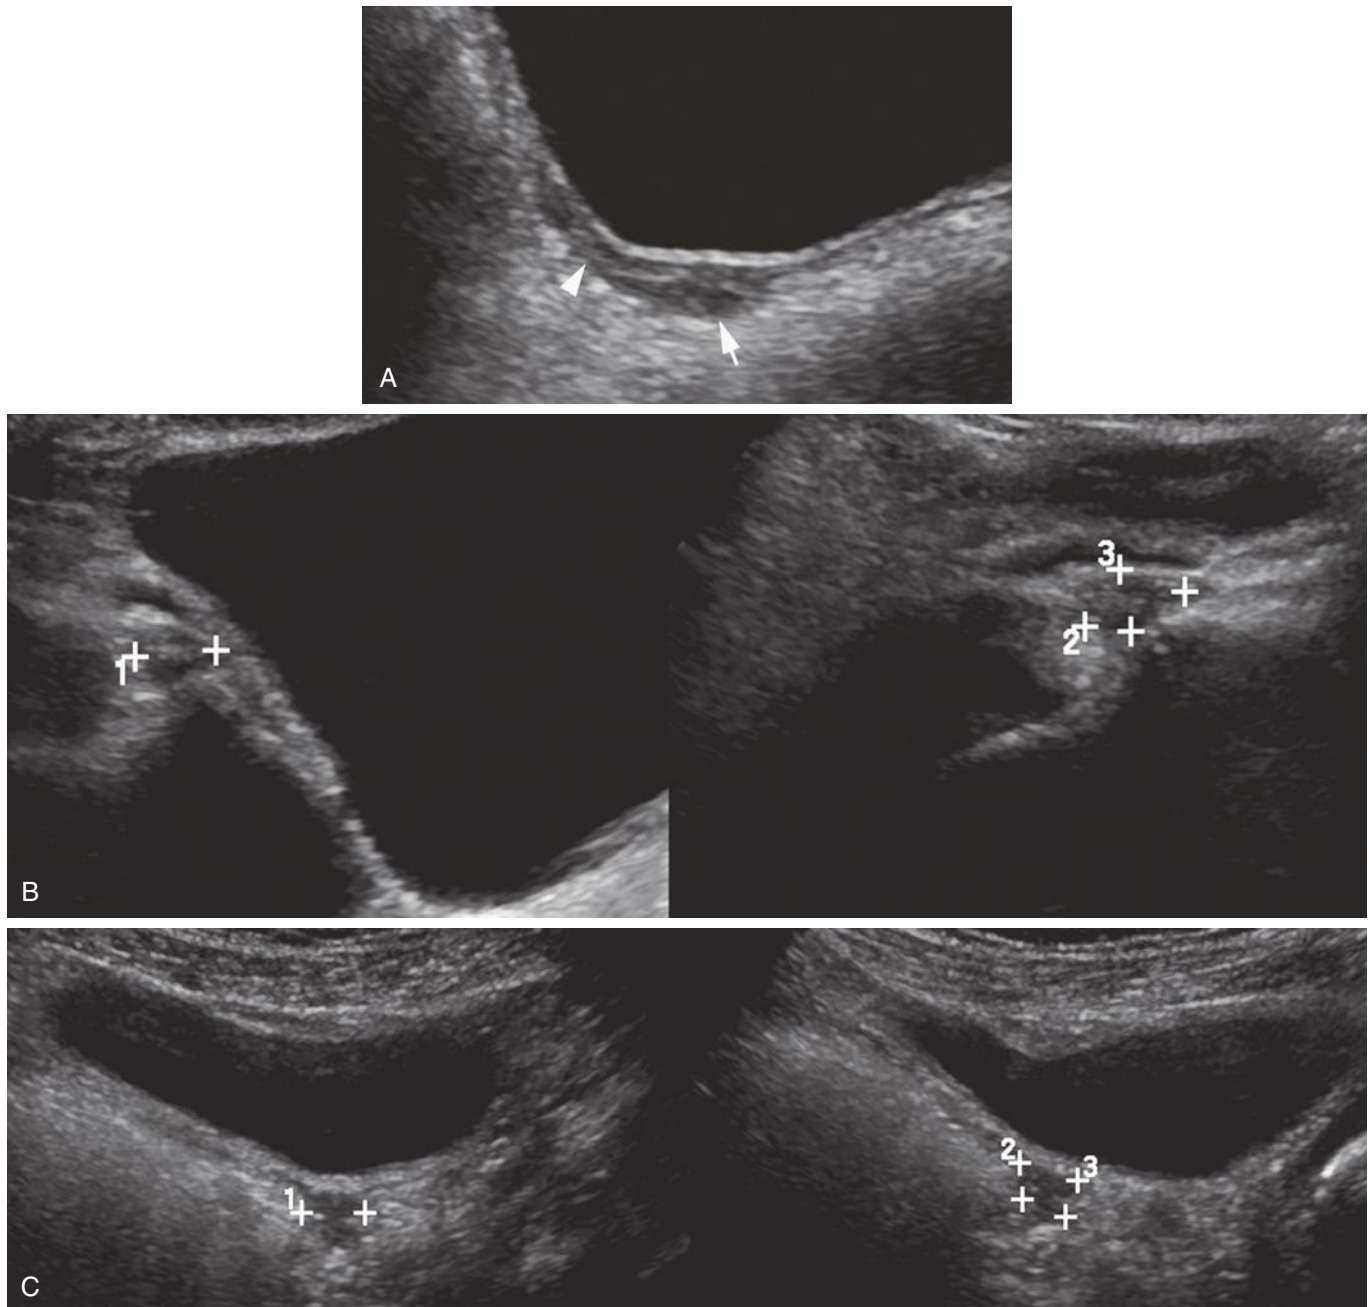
Turner mosaicism in a 14-year-old girl with short stature and premature ovarian insufficiency. A, Sagittal ultrasound image shows a juvenile uterine appearance posterior to the distended urinary bladder with relative prominence of the cervix (*arrow*) and a small, underdeveloped fundus (*arrowhead*). Transverse (left side of split screen image) and sagittal (right side of split screen image) ultrasound images demonstrate tiny right (B) and left (C) ovaries, each with a volume less than 1 mL.
